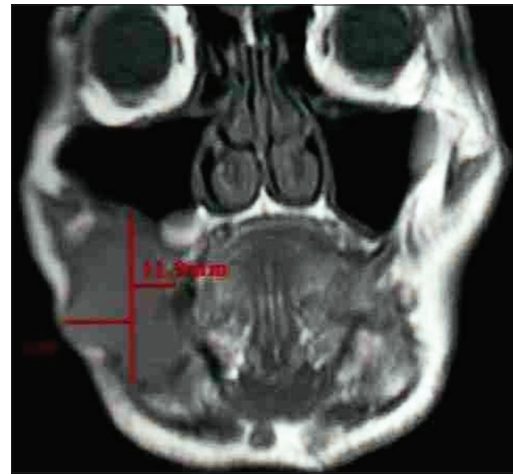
Tumor thickness on magnetic resonance imaging image (coronal view)
